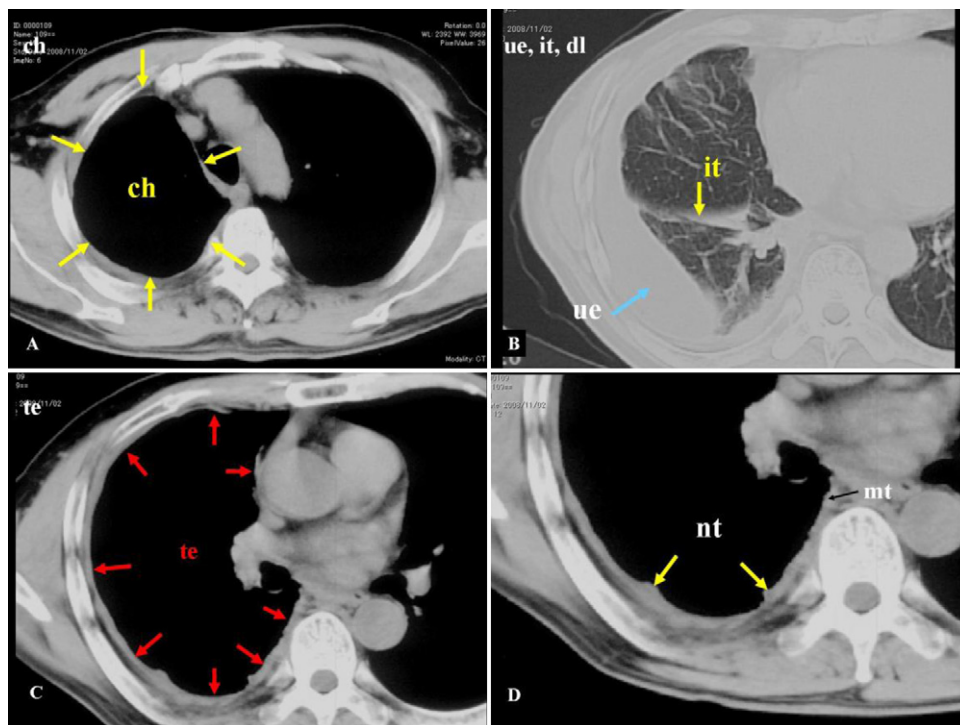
A 58 year-old man with diffuse desmoplastic MPM. CT scan shows contracted hemithorax (“ch”) leading to the right hemithorax volume loss (A). There is interlobar fissure pleural thickening (“it”), together with unilateral pleural thickening (“ue”), causing the lung volume diminished (“dl”) (B). The involvement of tumoral encasement of lung (“te”) (C), nodular pleural thickening (“nt”) and mediastinal pleural thickening (“mt”) (black arrow) on the right hemithorax are observed (D). MPM probability was agreed by experts as high MPM probability Grade 4 at advanced severity. This is a typical MPM case.
